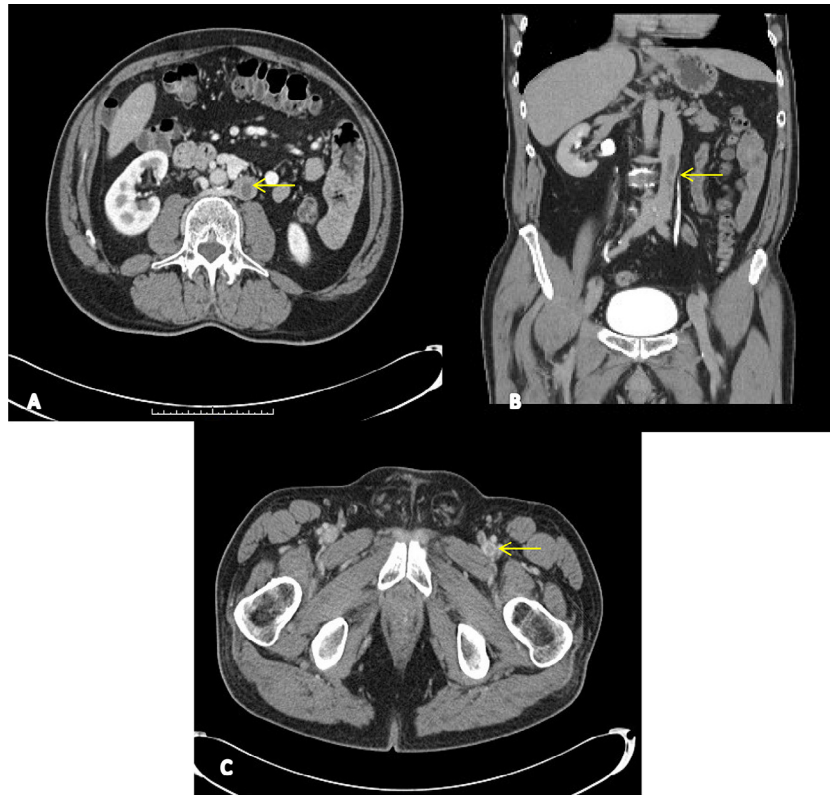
(A) Axial and (B) coronal computed tomography images depict thrombus in the infrarenal inferior vena cava and (C) the left femoral vein (yellow arrows).
